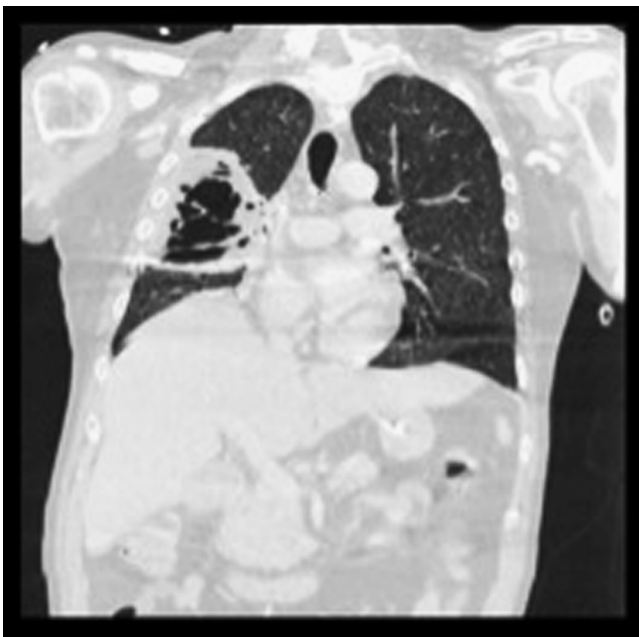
CT chest scan showing large intrapulmonary collection posterolaterally in right upper lobe measuring up to 14.5 cm with multiloculated gas and fluid. There is collapse consolidation of basal right lower lobe.
